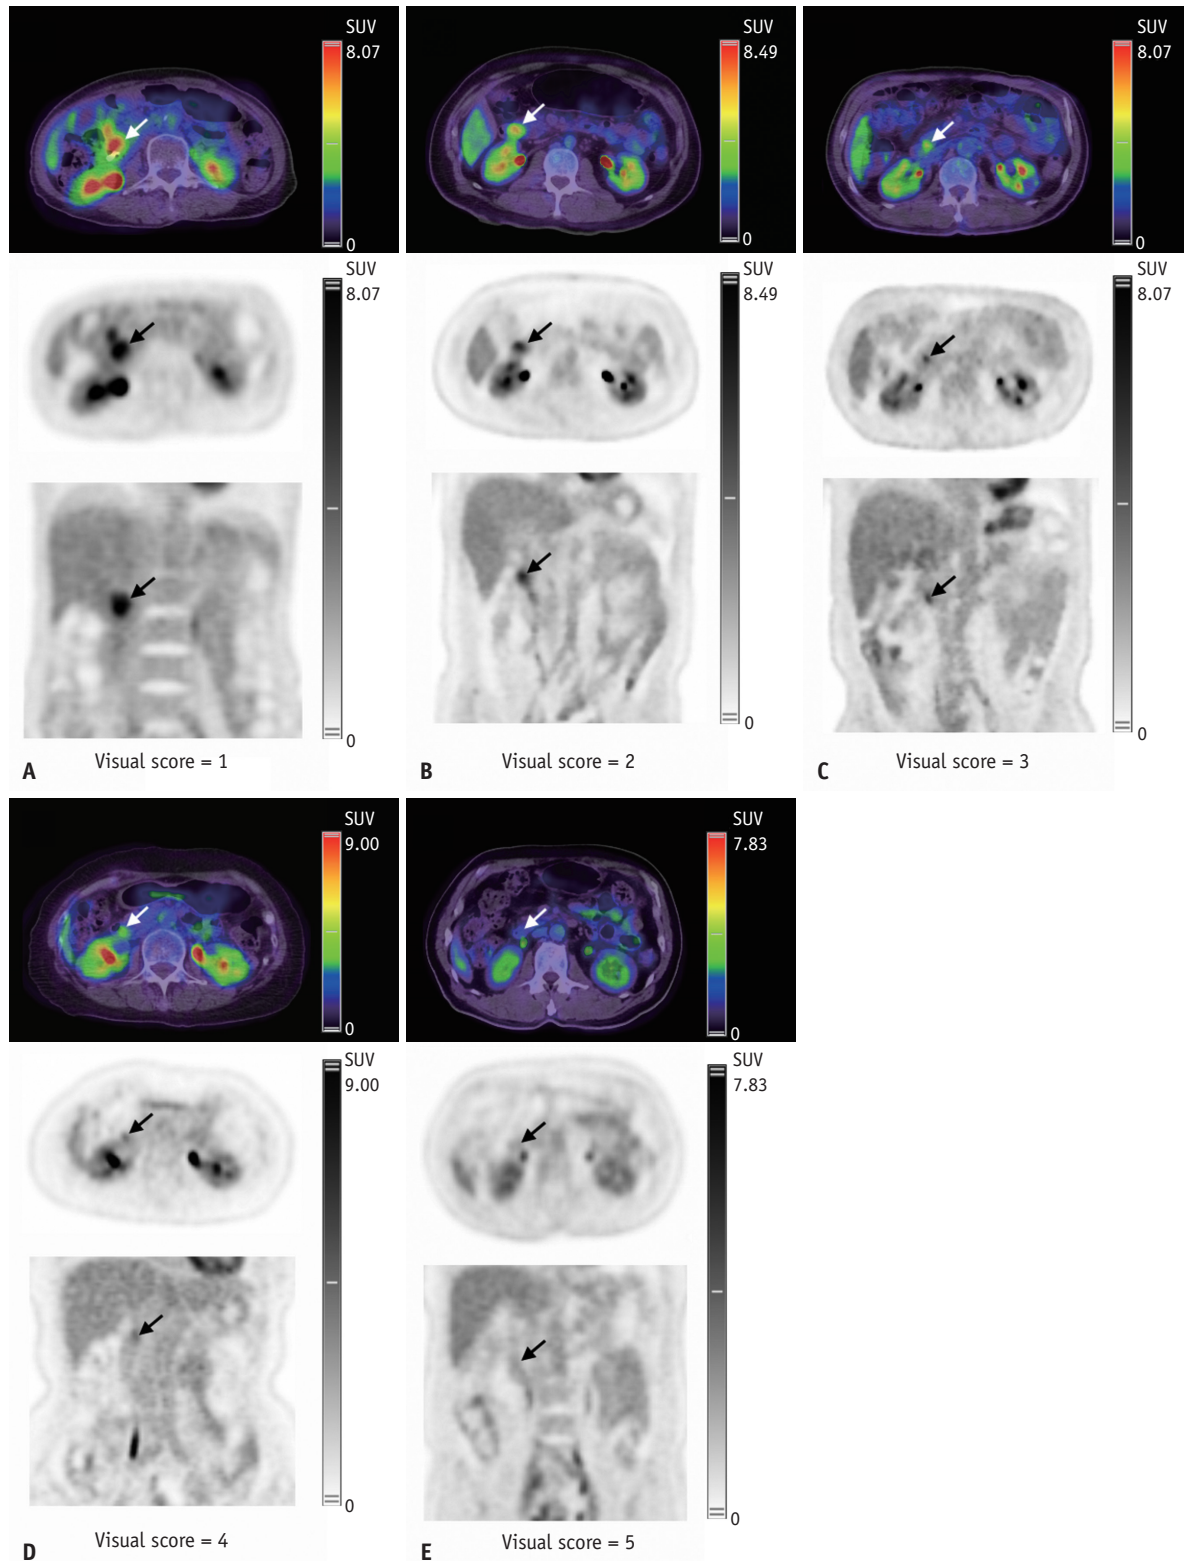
Demonstration of the positron emission tomography 5-point scale in the visual assessment of each ampullary lesions (arrows) in axial and coronal views. A: A definitively malignant lesion with focal and intense uptake greater than liver was graded with a visual score of 1. B: A likely malignant lesion with focal uptake greater than liver was graded with a visual score of 2. C: An equivocal lesion with mild, but focal uptake equal to or slightly greater than liver, was graded with a visual score of 3. D: A likely benign lesion with uptake equal to liver without focal activity was graded with a visual score of 4. E: A definitively benign lesion with uptake less than liver was graded with a visual score of 5. SUV = standardized uptake value
